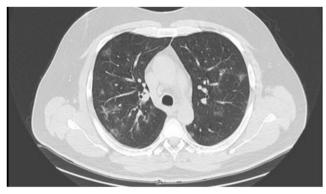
Thoracic CT scan of the patient
